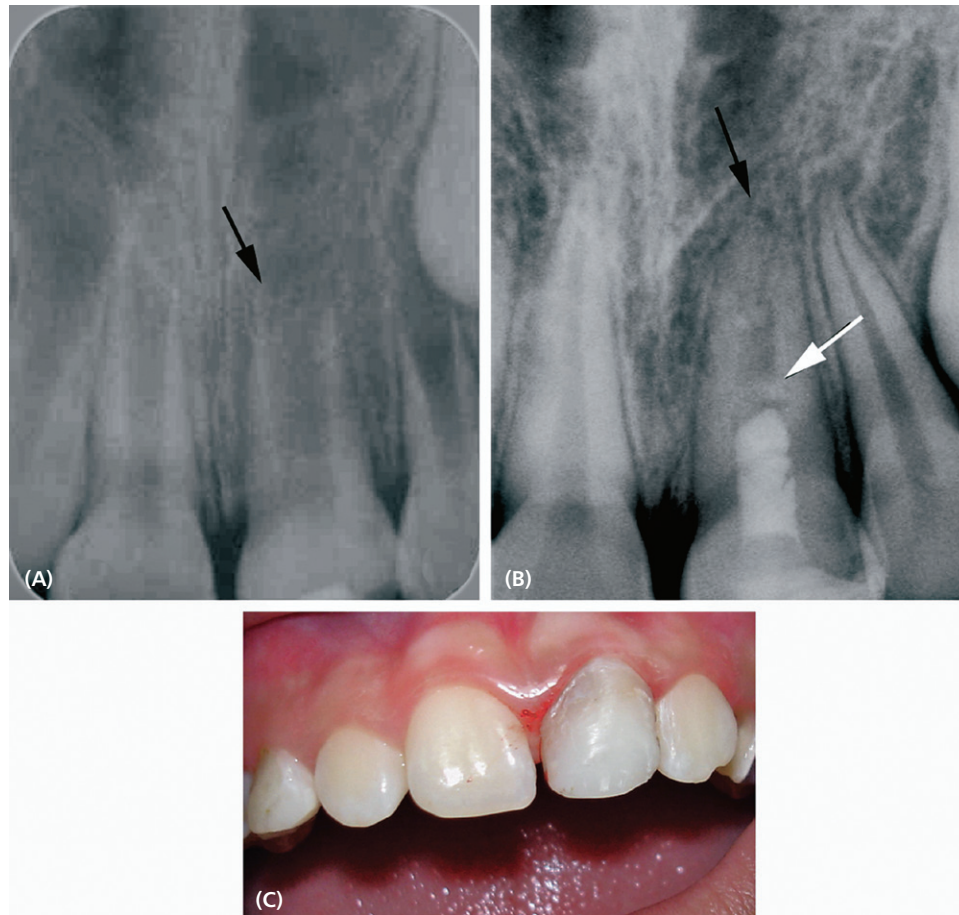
Comparison of dentinal wall thickness. A. Radiograph taken at initial presentation. B. Radiograph taken 30 months post treatment showing dentinal bridge formation (white arrow), increased root length, and apical closure (black arrows). C. Moderate discoloration of crown seen 30 months post treatment. (Reprinted with permission from Paniagua, 2010, with permission from CES Odontología.)
